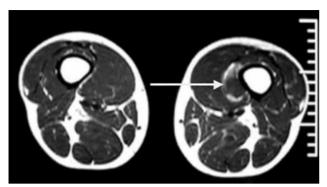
T1 weighted magnetic resonance imaging of the tumoral mass (arrow).
